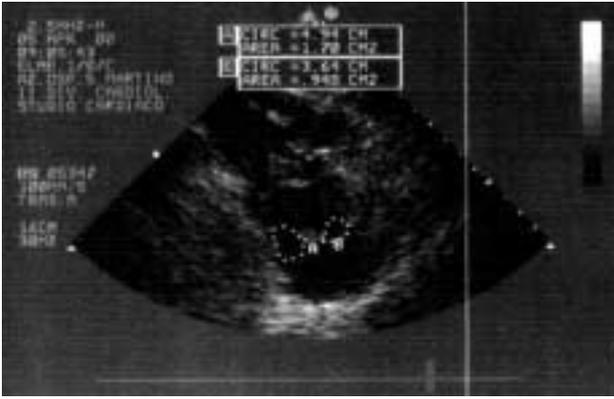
Parasternal short-axis view of the mitral valve (diastole). Two unequal areas of mitral opening are divided by the image of the repair suture. A = coaptation point; B = lesser mitral orifice.
